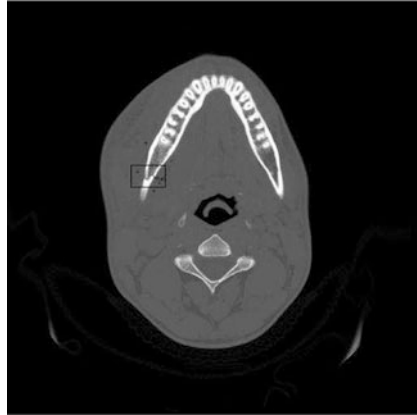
CT scan of a mandible with a minor fracture (within the *black rectangle*)
